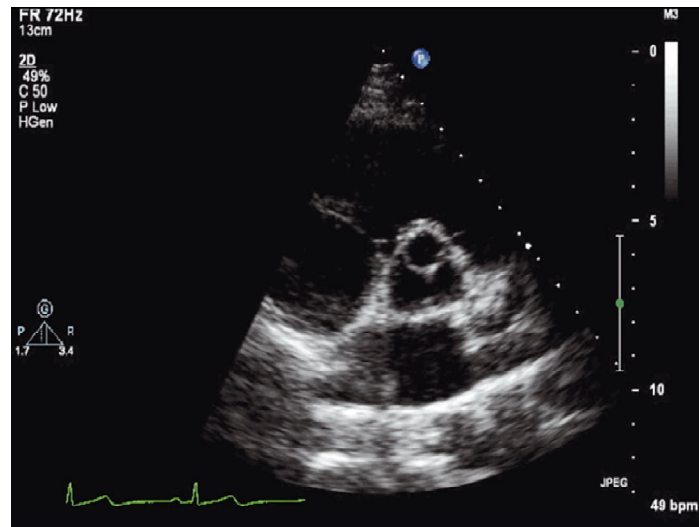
shows normal parasternal short axis view (aortic valve level) (Houghton, 2013)..
